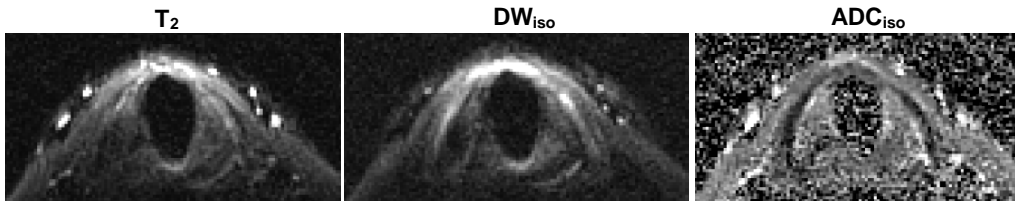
DWI of larynx: 6 axial slices (only 1 shown), $0.78 \times 0.78 \text{ mm}^2$ in-plane resolution, 3 mm slice thickness, 0.4 mm slice spacing, $10 \times 5 \text{ cm}^2$ FOV, readout in R/L direction, TE = 69 ms, b = 750 s/mm^2 , 3:40s total scan time, using a custom built 3-channel anterior neck coil.
